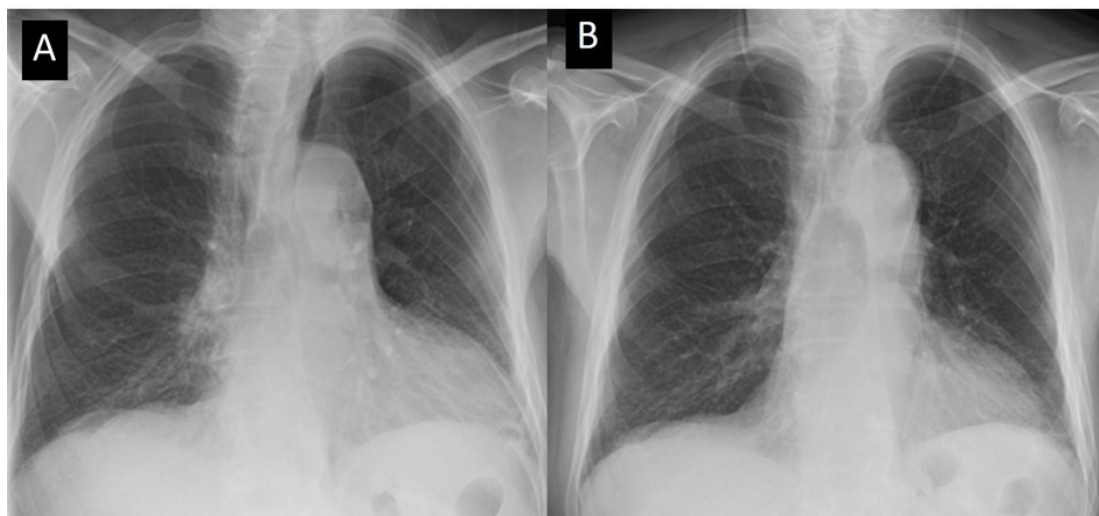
Chest roentgenography showing nonspecific reticular opacities due to bradycardia and hypotension (A) and recovered after the treatment (B).
